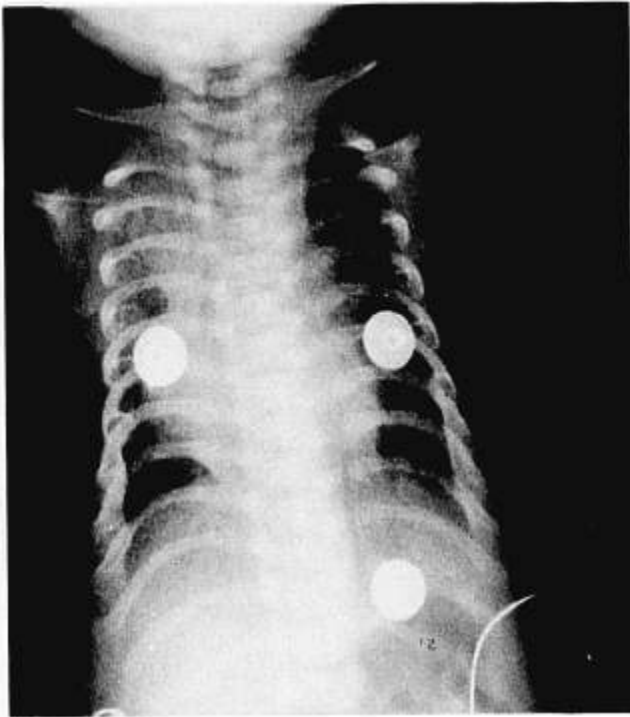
Thoracic roentgenogram of patient no. 1. Abnormalities include high clavicles, narrowed thoracic cage with horizontal, short stubby ribs with a widened anterior portion, and right upper lobe atelectasis.
